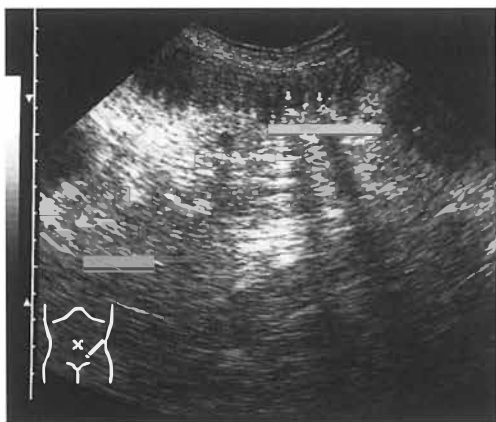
Ultrasonogram showing calculi in the distal ileum.
